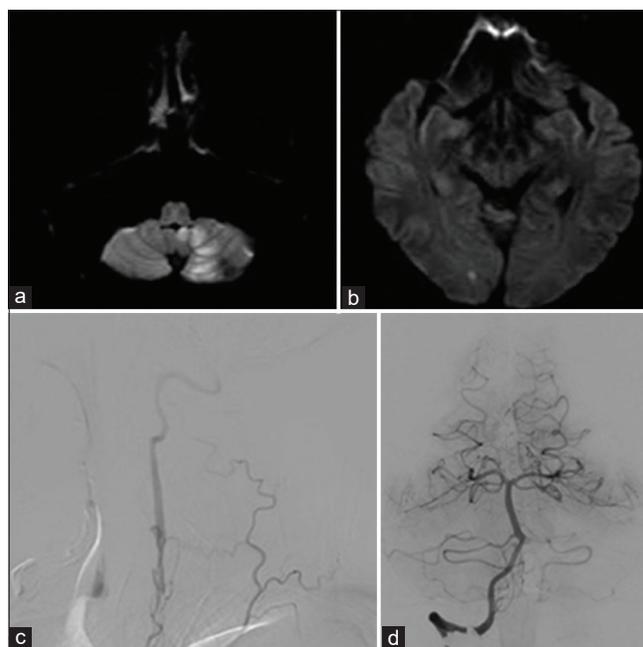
(a and b) Magnetic resonance images showing left cerebellar infarction and right occipital lobe infarction. (c) Left subclavian artery angiography showing antegrade vertebral artery slow flow from the collateral vessels. (d) Right vertebral artery angiography showing the dominant right vertebral artery.
